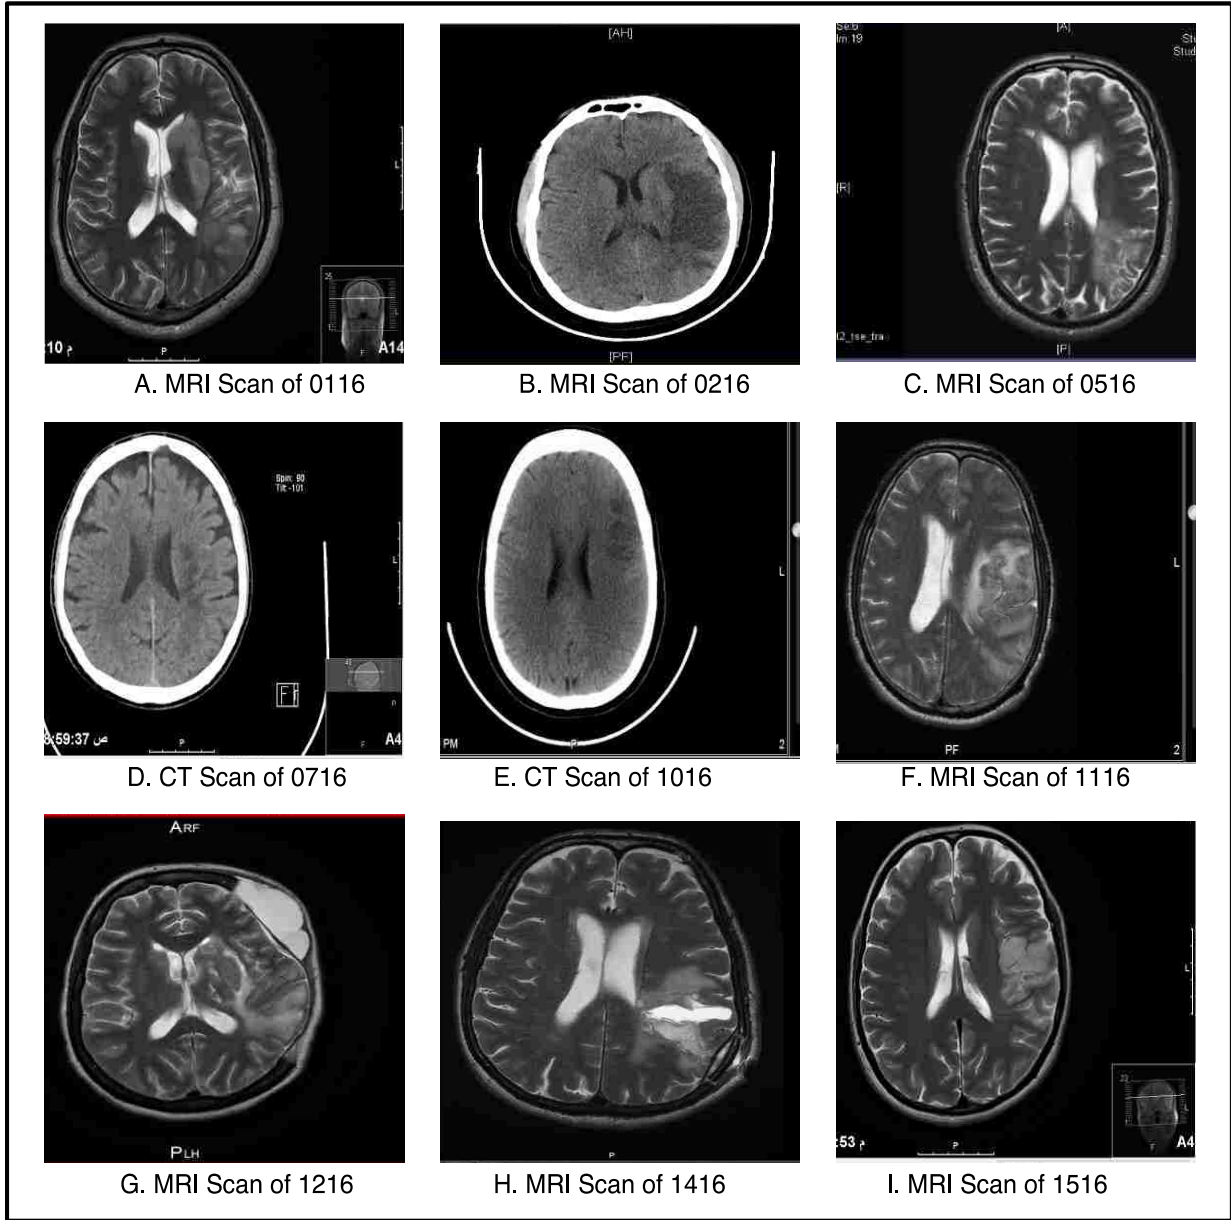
MRI and CT Scan images for nine participants.
